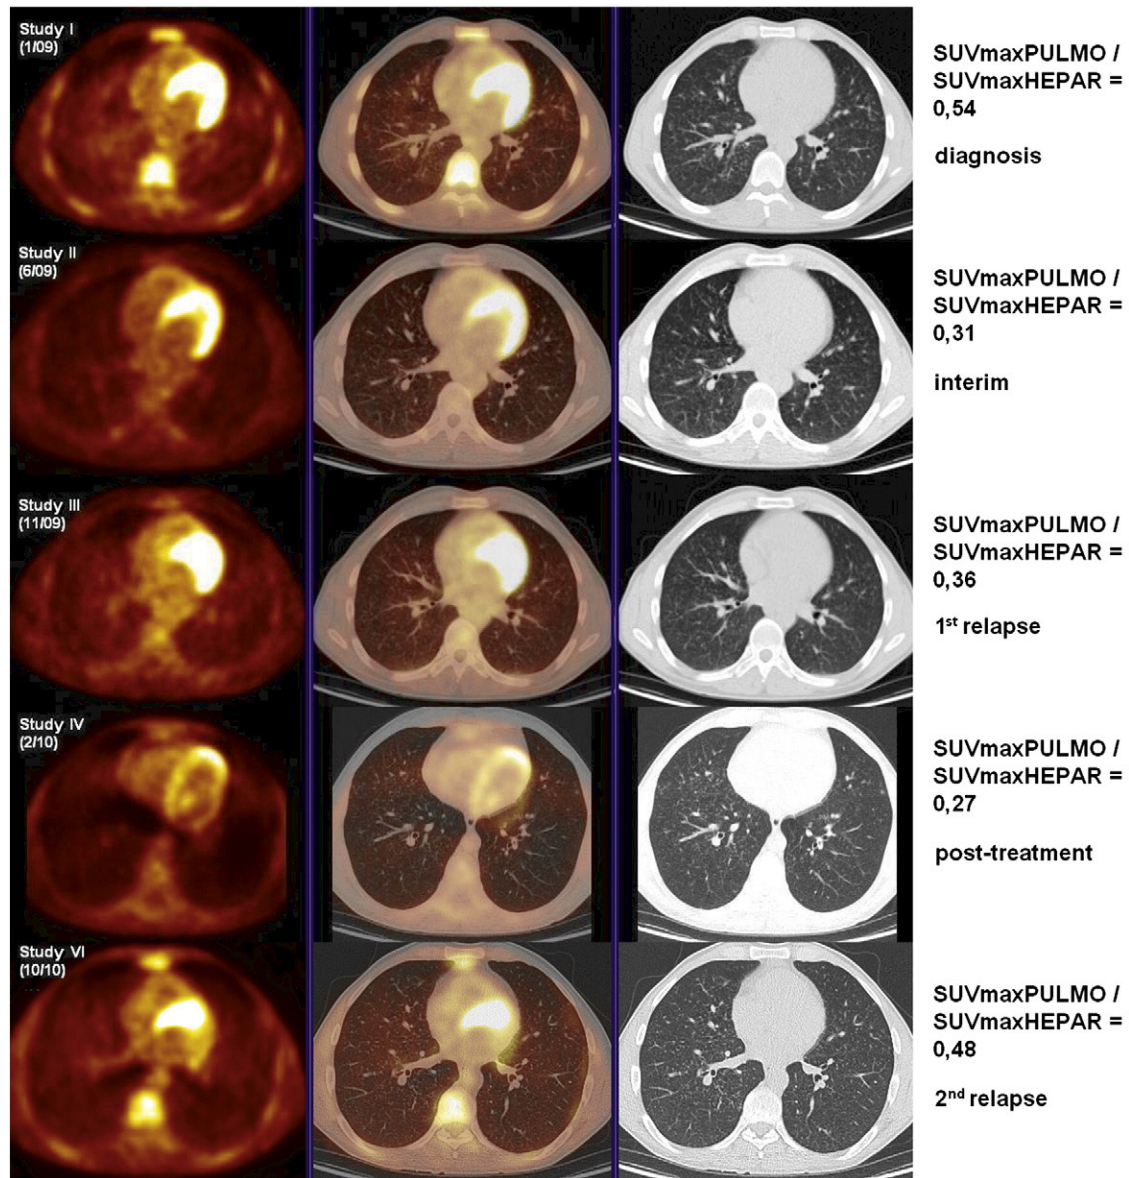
Series of FDG-PET/CT images of a patient with multisystemic Langerhans cell histiocytosis with pulmonary involvement (male, born 1973). High index value on admission PET/CT together with pathognomonic HRCT finding (multiple small nodules with sporadic cysts) and clinical symptoms (dyspnea, cough) was diagnostic for PLCH. Interim PET/CT after two cycles with cladribine shows a therapy response which correlated with regression of lymphadenopathy and relief of the symptoms, including perianal pruritus and B-symptoms (night sweats, fever and weight loss). However, an aggressive form of Langerhans cell histiocytosis with recurrent relapses was the case. The index value corresponded closely with the disease course. We consider myocardial FDG uptake to be physiological.
